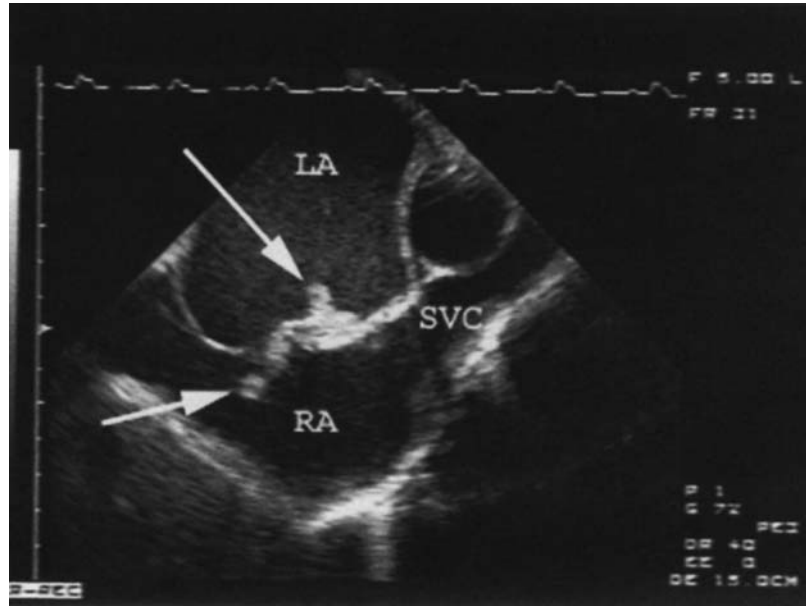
Longitudinal transesophageal echocardiographic imaging in the mid-upper esophagus. Arrows point to a thrombus wedged through a patent foramen ovale and lodged in both the right atrium (RA) and left atrium (LA). SVC = superior vena cava. (From Kerut, E. K. et al. (2001). *J. Am. College Cardiol.*, 38(3), 619.)
